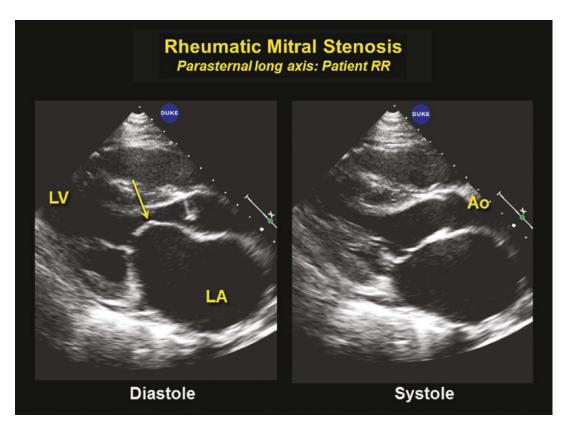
Two-dimensional echocardiographic parasternal long axis view of rheumatic mitral stenosis showing tethering of the anterior mitral valve leaflet tip. The
